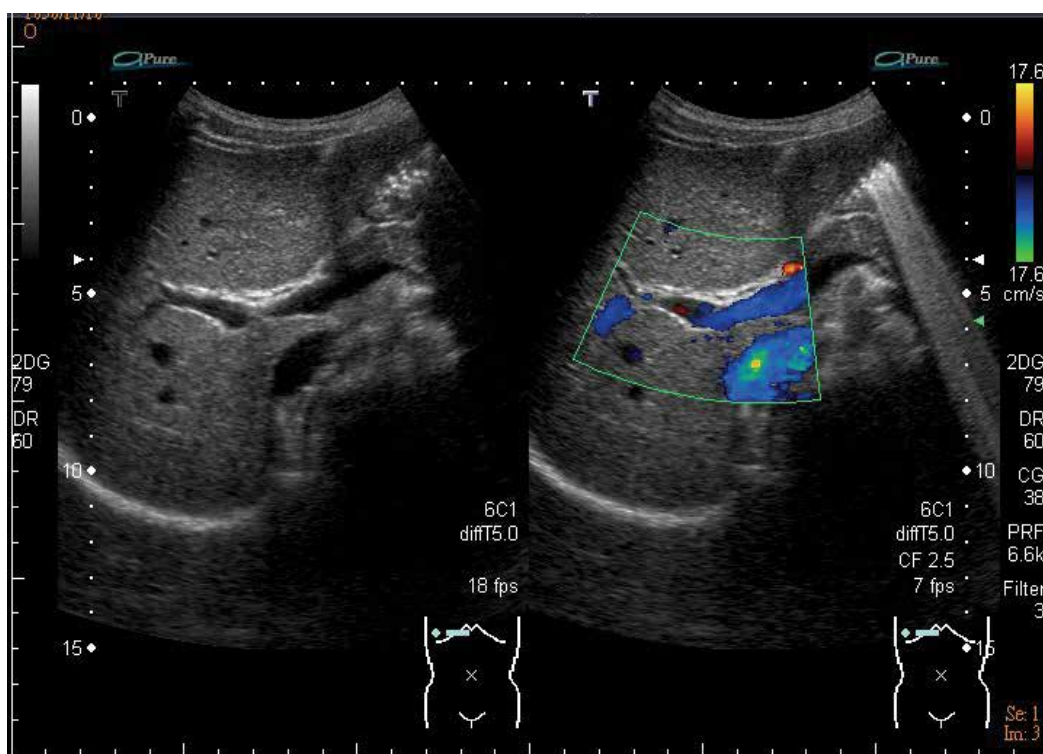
Normal presentation of CBD Left: The CBD lies just anterior to the portal vein in porta hepatis and three echogenic lines will be seen. The first line closest to the probe will be the anterior wall of the CBD. The second line is the shared wall of the CBD and portal vein. And the third line is the posterior wall of the portal vein. Measurement of the caliper of CBD is usually done between the interior margin of the anterior and the posterior wall. Right: The CBD and portal vein can be easily differentiated by color Doppler. The portal vein will demonstrate flow and the CBD will not. (CBD: common bile duct)
